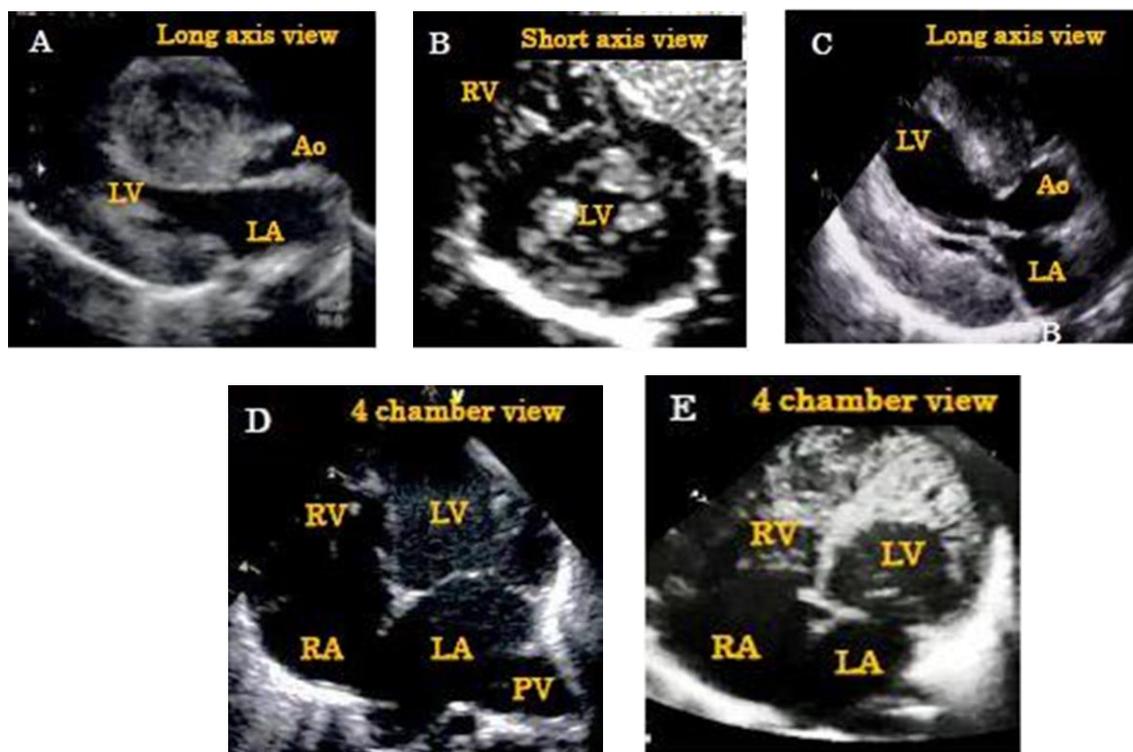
Transthoracic echocardiography shows hypertrophic cardiomyopathy on the parasternal long-axis view in case
